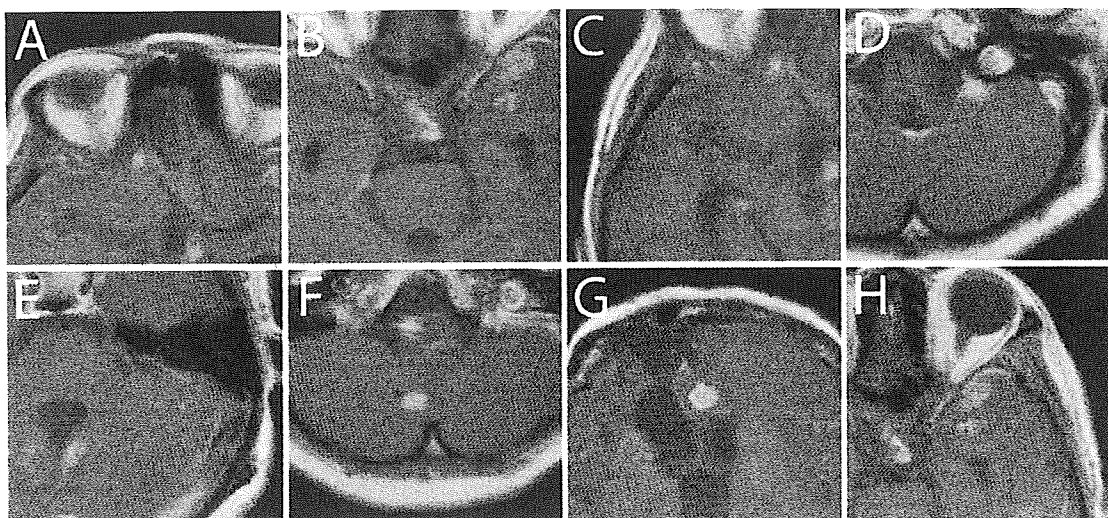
Gadolinium-enhanced T1-weighted MRI at 60 months. A–H correspond to the lesions treated with SRS shown in Fig. 3A–H.
